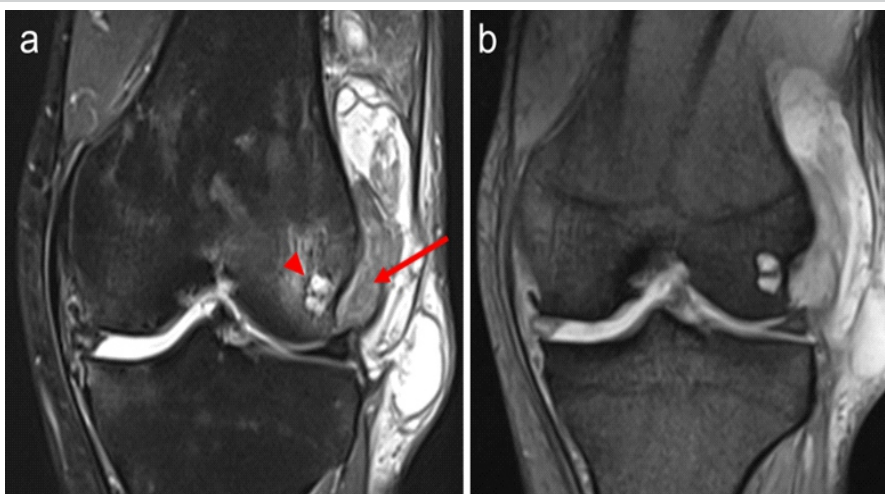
MRI of the left knee. (a) Coronal fat suppressed PD-weighted image demonstrates a mass-like intra-articular lesion at the lateral side of the knee joint. The popliteus tendon is partly engulfed by the lesion (long arrow). Subjacent cortical erosions of the lateral femoral condyle are noted at the level of the popliteal sulcus (arrowhead). Associated overlying bursitis and small joint effusion are also evident. (b) Coronal Gradient Echo sequence revealing no blooming, denoting absence of hemosiderin deposits.
